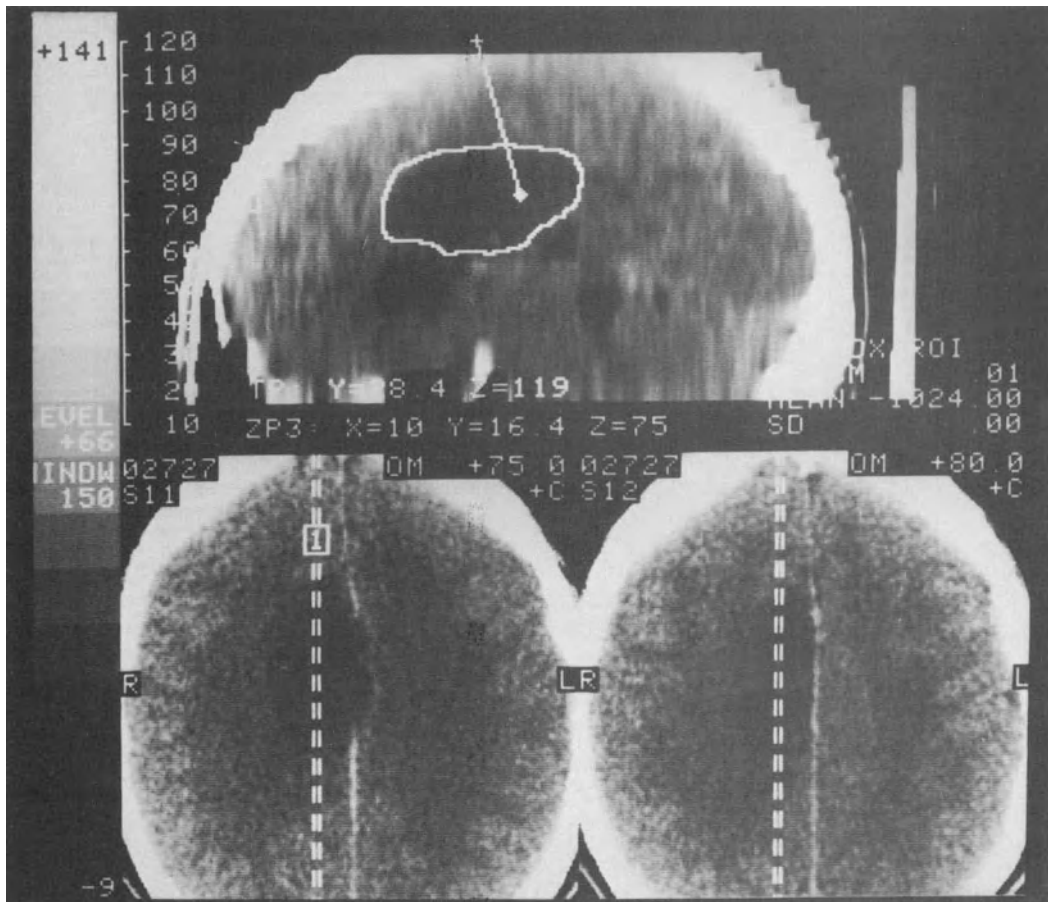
CT sagittal reconstruction of the brain tumor traced by the electronic trace feature of the CT scanner. The first implantation point and the trephination point are marked. Because the coordinate systems coincide, the coordinates measured by this procedure are the same as for the stereotactic device.
